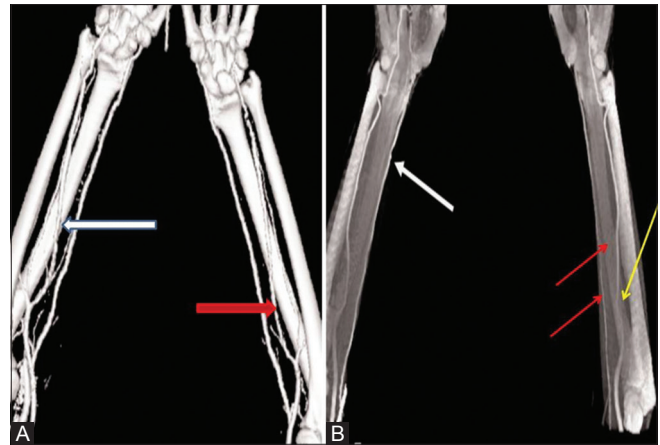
(A and B): (A) Computed tomographic angiography shows an anterior projection of diffuse calcific disease of the radial and the ulnar artery. The calcification of the branches from the radial and the ulnar arteries has been shown (red and white arrow). The radial arteries of the bilateral arms are patent but diffusely calcific; (B) Anterior projection of computed tomography shows high bifurcation of radial artery above the elbow joint. There is no bifurcation
